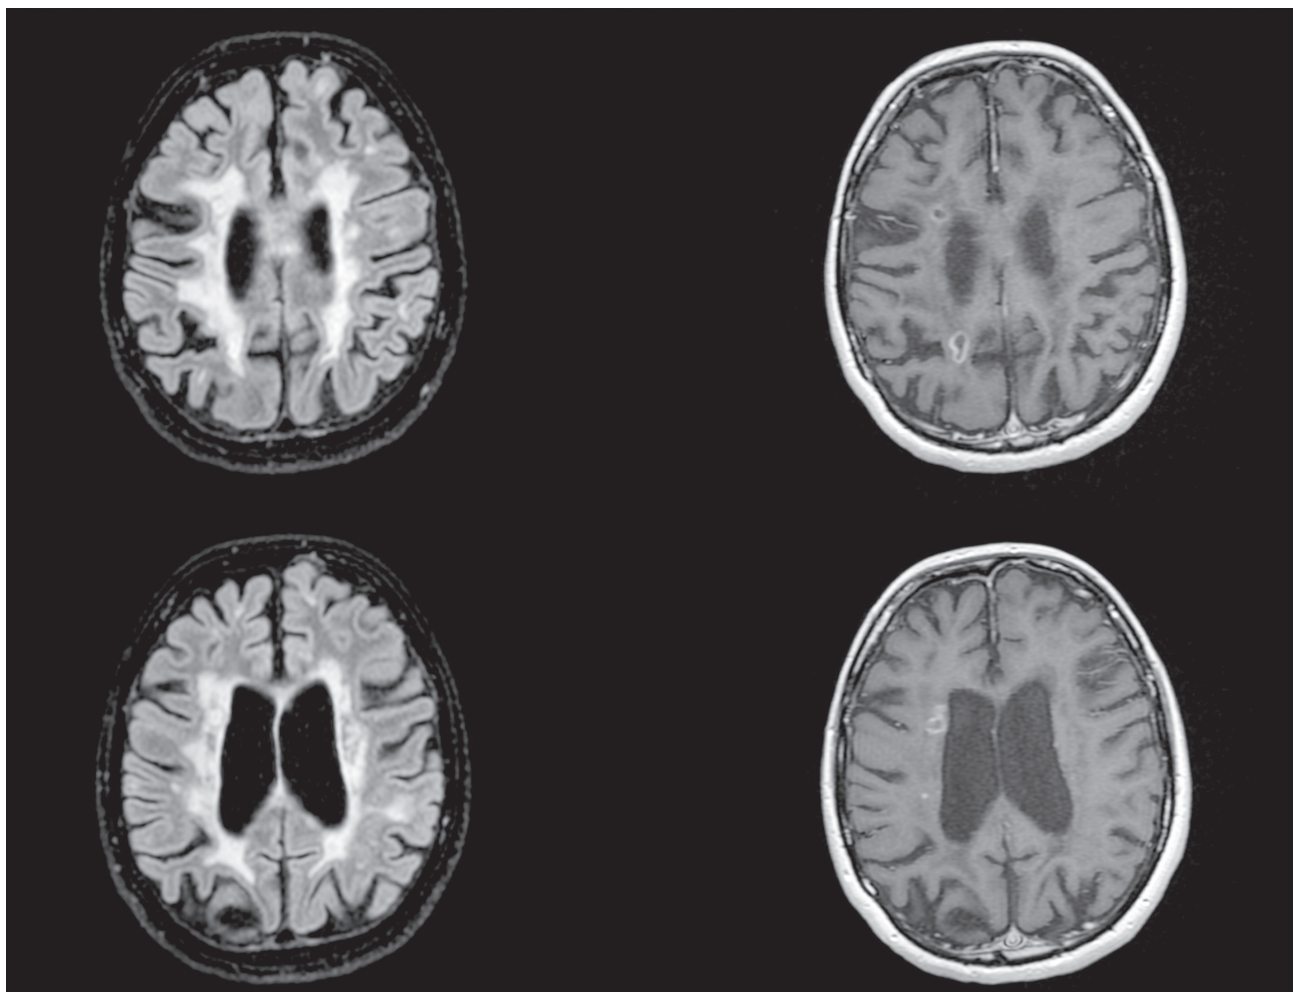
Aquisições de RM, nos mesmo planos, antes (esquerda) e após (direita) administração de GD endovenoso. À direita individualizam-se múltiplas lesões com realce em anel/nodular, traduzindo atividade inflamatória aguda no seio das áreas de desmielinização confluyente, representadas à esquerda pelo hipersinal nas sequências FLAIR.
